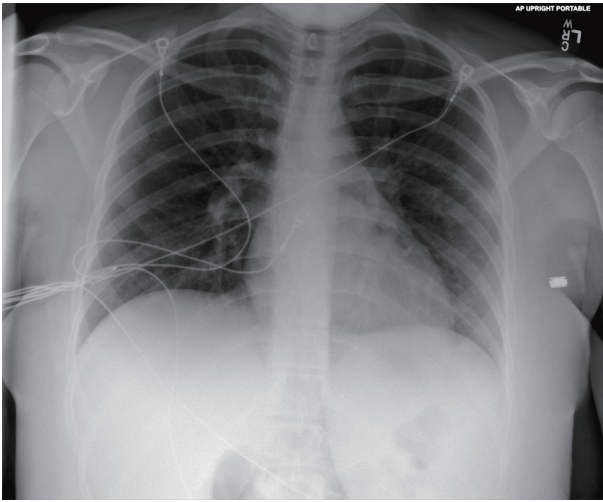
Anteroposterior (AP) chest X-ray from initial emergency department visit.
